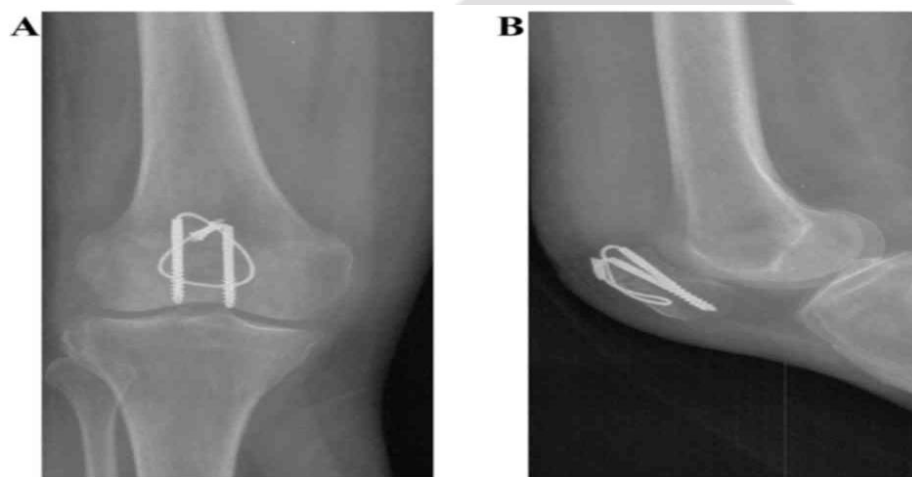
Postoperative radiographs 8 weeks after surgery. (A) A postoperative radiograph. (B) A postoperative lateral radiograph demonstrating the anatomical reduction.
